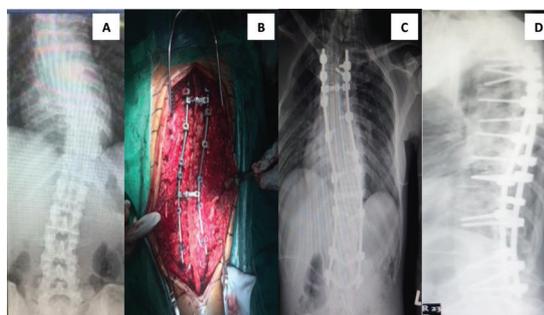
(A) Spinal plain x-ray of another AIS patient show scoliosis of right thoracic, ribs prominence adjacent to the convexity; (B) intraoperative view of scoliosis surgery; (C, D) postoperative radiograph views of pedicle screw-rod system
